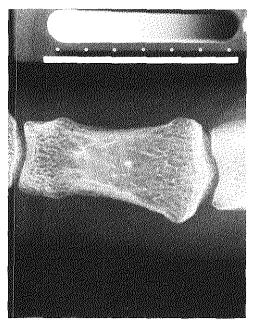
Radiograph of phalanx with a coarse bone pattern.
